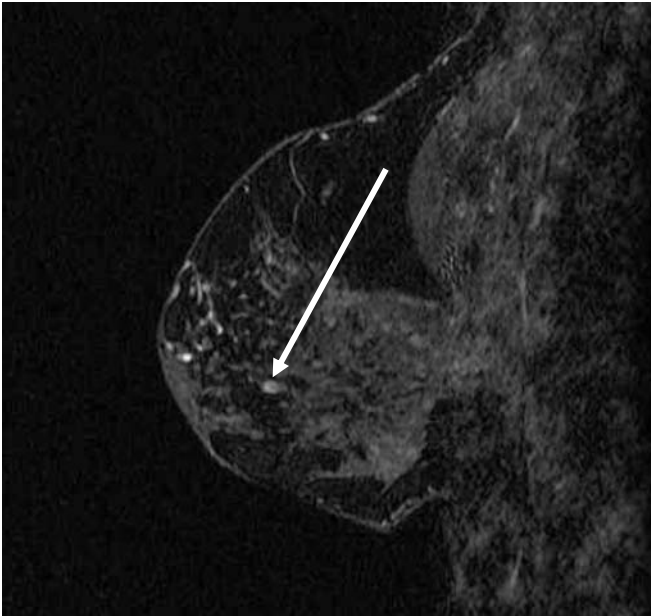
Invasive ductal carcinoma, 3 mm in diameter. This lesion was incidentally detected in a 51 y/o woman who presented for staging MRI of a tumor elsewhere in the breast [not shown]. Note suspicious rim enhancement. Dynamic imaging also showed rapid initial contrast uptake followed by early transition to a plateau of signal intensity.
